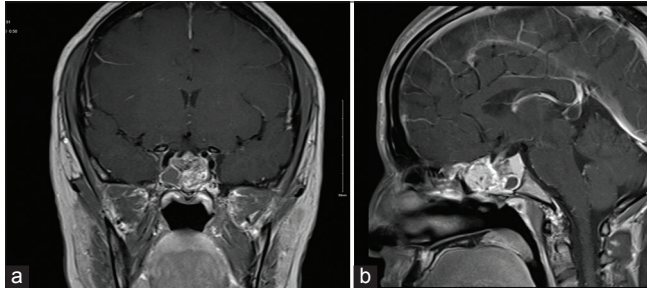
(a and b) preparative coronal and axial T1-weighted MRI with contrast and (c and d) preparative coronal and sagittal T2-weighted MRI.
